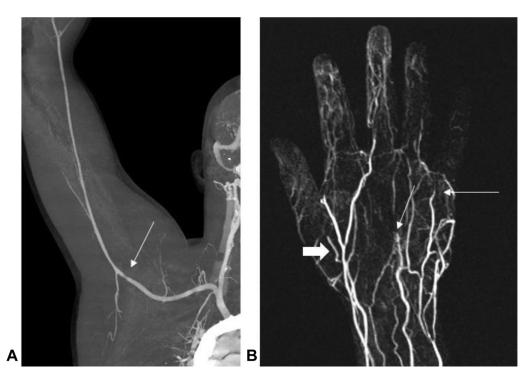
Angiography of the right upper extremity of a 19-year-old male baseball pitcher who presented with intermittent numbness and discoloration of the little finger following a throwing session. A CT angiogram of the shoulder and brachium demonstrating occlusion of the axillary artery (solid arrow). B MR angiogram of the right hand with multifocal occlusions of the princeps pollicis (thick solid arrow), and multiple common digital arteries (thin solid arrows) with resultant severely decreased perfusion to the little finger, and somewhat decreased perfusion to the thumb and ring finger.
